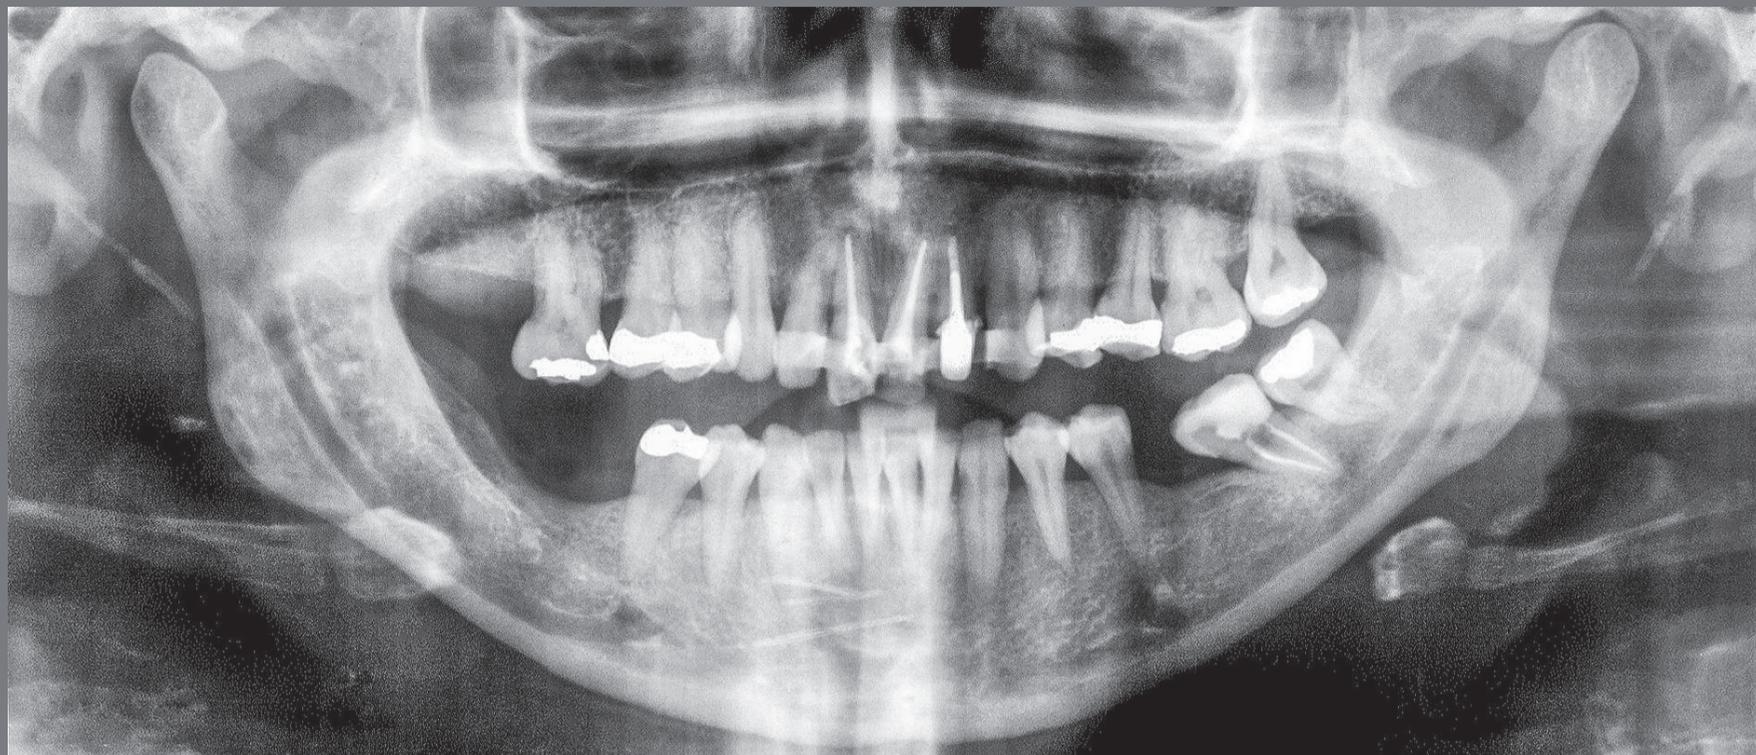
Initial panoramic radiograph.
